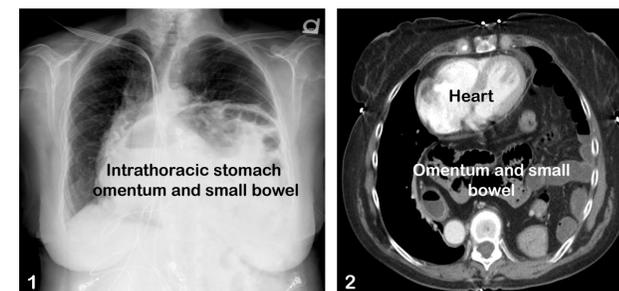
Intrathoracic stomach with herniated omentum and small bowel on chest X-ray (1). The CT scan shows herniated omentum and small bowel (2).
